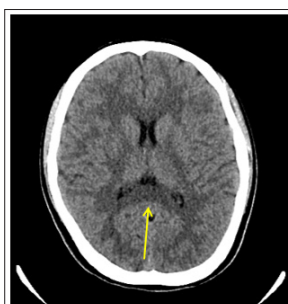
Axial non-contrast CT of the head demonstrates no acute finding. Note that the splenium is normal in appearance (arrow)
